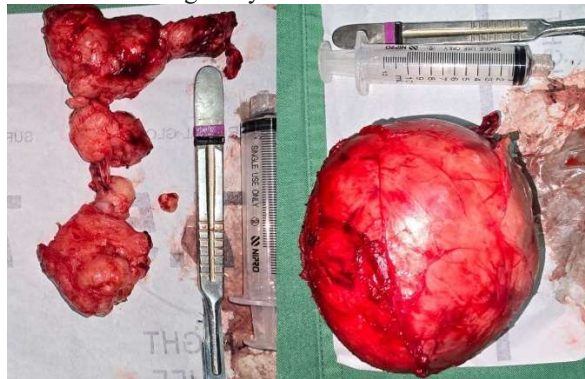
The left image shows the excised prostate, and the right image shows the pelvic tumor previously detected on ultrasound and CT scan.
